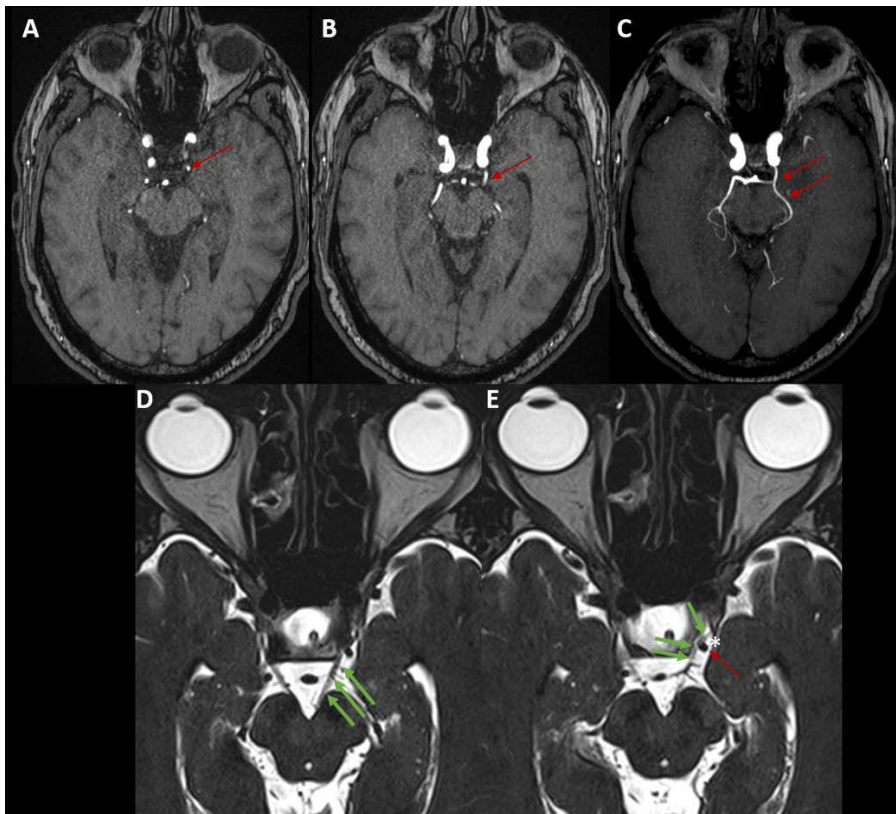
54-year-old male presenting with oculomotor neurovascular conflict. Brain MRA on axial 3D-TOF sequence (A-C) and orbits MRI on axial 3D-CISS sequence (D and E). Fetal left PCA (red arrows) with prominent P-Com artery, better seen on the Maximum Intensity Projecting (MIP) reconstruction (C). On the bottom, greater conspicuity of the left-sided neurovascular conflict, between the medially displaced distal cisternal oculomotor nerve (green arrows) at the cavernous sinus entrance and the fetal left PCA, along the superolateral aspect of the nerve. The left oculomotor cistern was also slightly distended (*).
